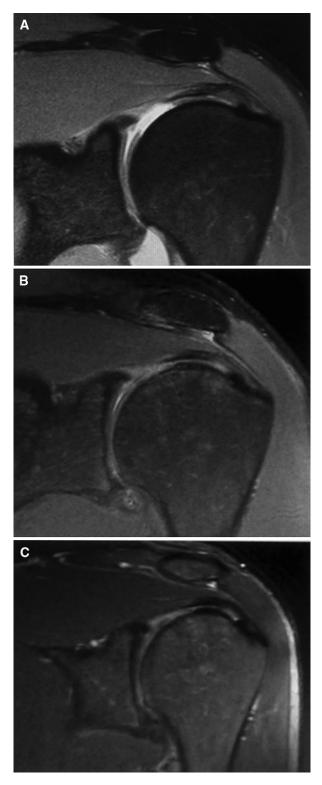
MRI assessment of patient 4 (fat-suppressed PDw TSE coronal sequences): preoperative humeral cartilage lesion (MR arthrography) (A) repair tissue with generalized hyperintensity 3 months postoperatively (B) and repair tissue with reduced hyperintensity 11 months postoperatively (C).
